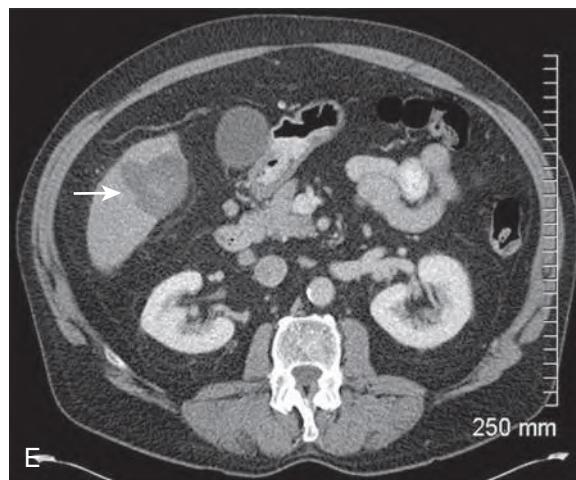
Microwave ablation of hepatocellular carcinoma (HCC). A, Arterial phase contrast-enhanced computed tomography (CT) scan demonstrates a 2.5-cm hypervascular mass (arrow) in the right hepatic lobe of a patient with hepatitis C. B, There is washout (arrow) on the portal venous phase consistent with HCC. C, Ultrasound image shows the hypoechoic mass with placement of the echogenic microwave probe in the mass. D, Ultrasound image during microwave ablation depicts the hyperechoic zone of ablation.
